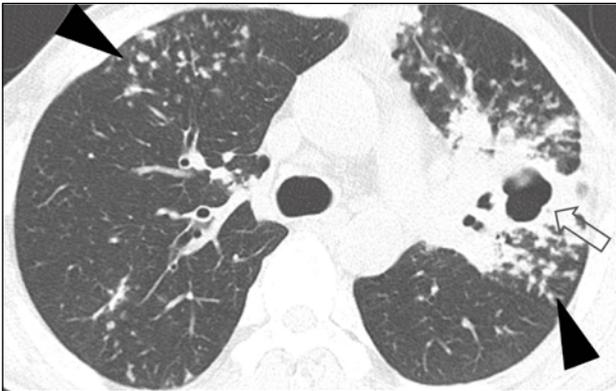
Drug-sensitive tuberculosis in a 40-year-old man: a transverse thin-section computed tomography scan shows one cavity in left lingular segment (open arrow) and multiple centrilobular nodules in both upper lobes and superior segment of left lower lobe (arrowheads).
